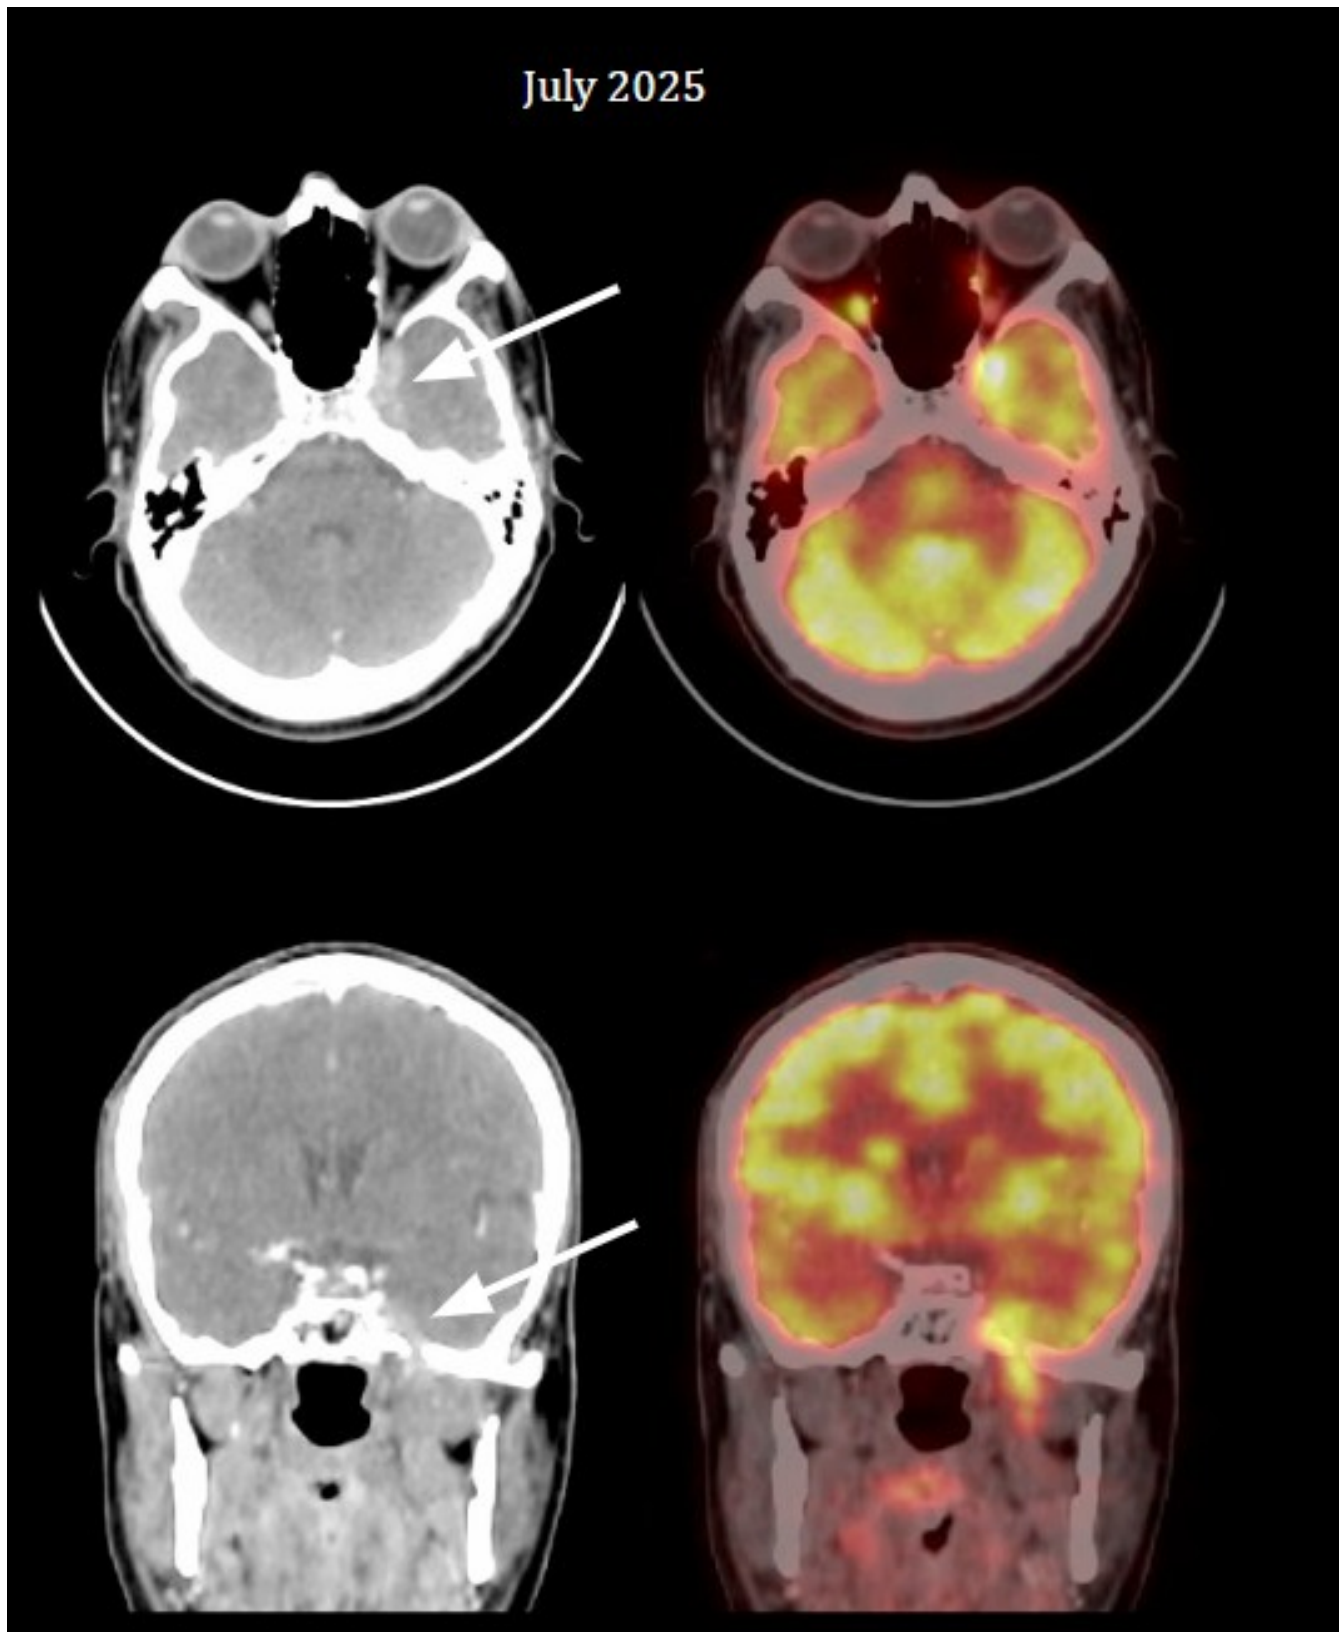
Axial and coronal CT and fused PET/CT images (July 2025) showing extension of the lesion into the left infratemporal fossa, with superior extension into the middle cranial fossa (arrow). The lesion abuts the left temporal lobe without associated perilesional edema, best appreciated on the left-hand contrast enhanced CT images.
